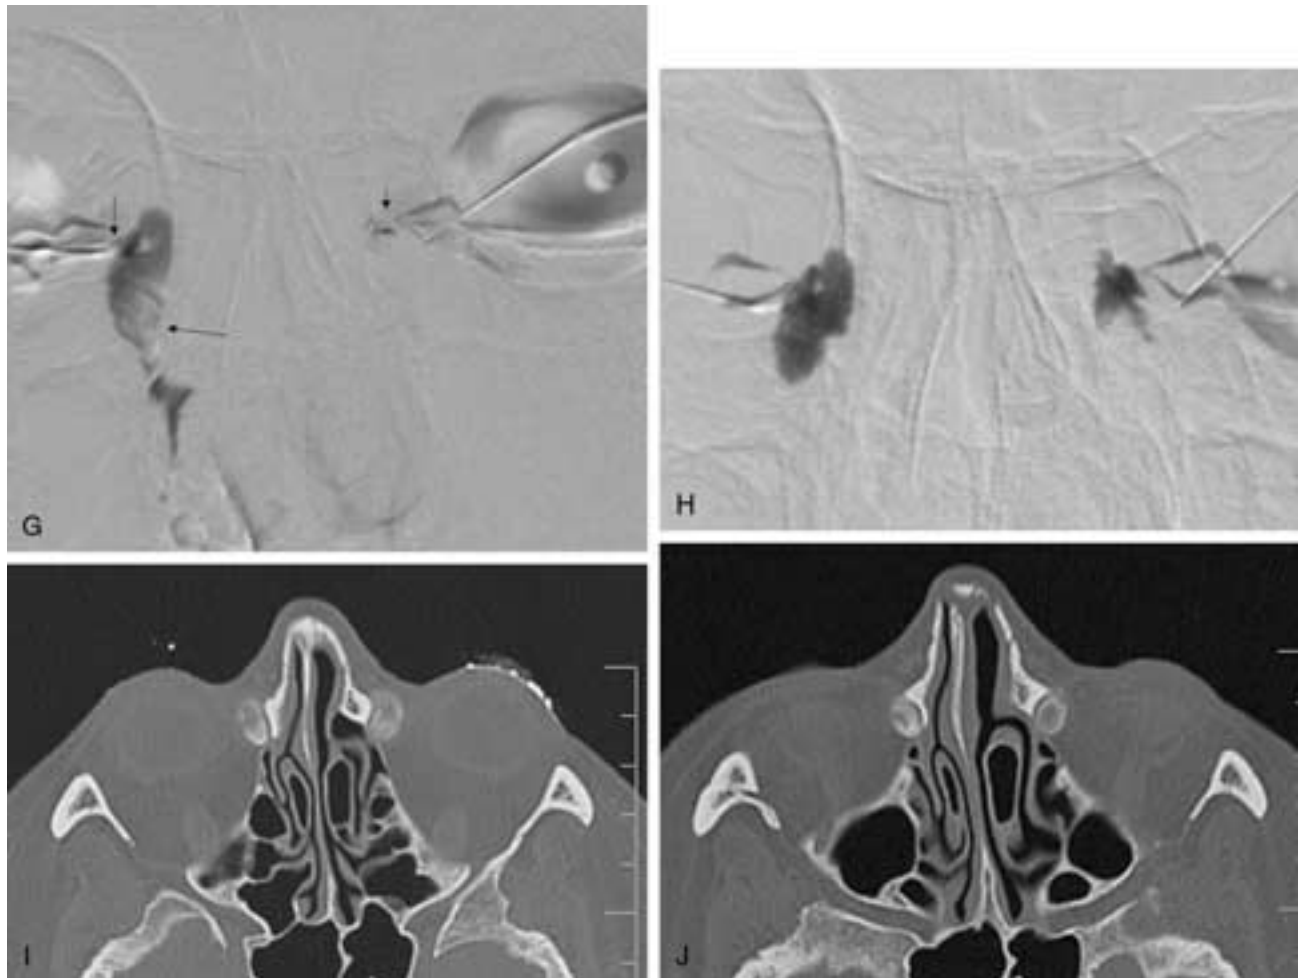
Continued. G to N, Lupus patient with bilateral tearing and intermittent facial swelling. G, DCG shows minimal filling of a stenosed left common canaliculus (*short arrow*). Contrast refluxes into the conjunctival sac. The right lacrimal sac is distended with secretions and debris (*horizontal arrow*) in the inferior medial aspect of the sac. Stenosis of the right superior canaliculus (*vertical arrow*). H, Repeat DCG study. Left lacrimal sac was distended and irregular, with a filling defect in the inferior aspect. Distended irregular right lacrimal sac. Contrast was not entering the nasolacrimal duct bilaterally. I and J, CT-DCG. Axial images show filling defects within the right and left lacrimal sacs.
